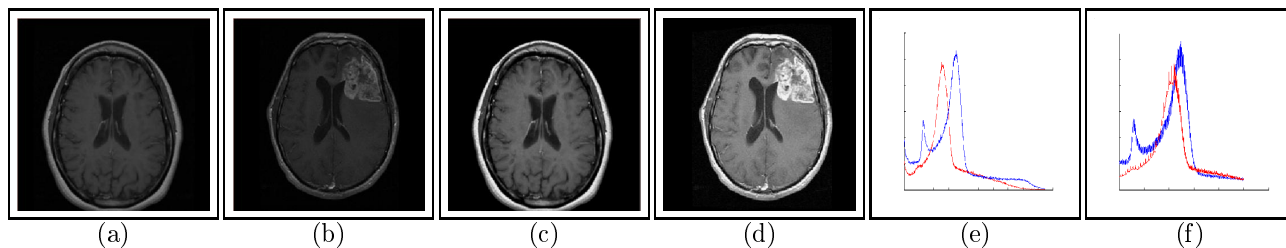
Slices of (a) a normal T1-weighted scene of the brain, (b) a T1-weighted scene of the brain with a tumor, both taken after gadolinium administration, and (c), (d) the scenes in (a), (b) after intensity standardization by using the histogram landmark-based method in,¹⁰ and (f), (g) the intensity histograms of the scenes in (a) and (b), and (c), (d), respectively.
